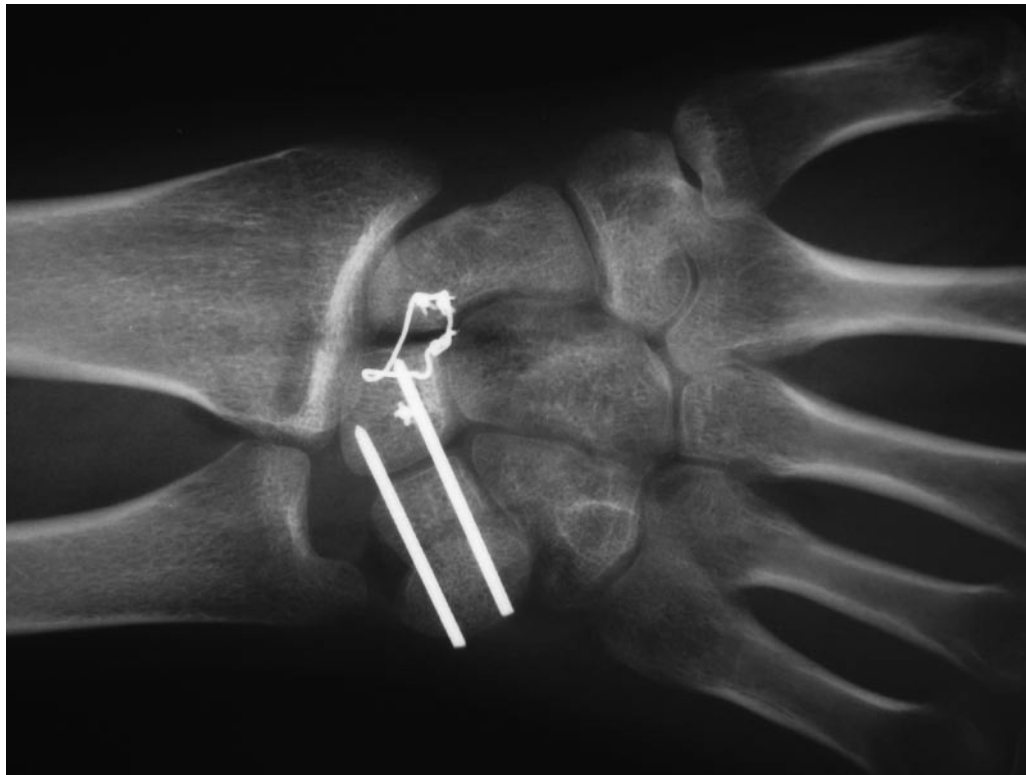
Postoperative PA and lateral radiographs of a volar lunate dislocation treated with a combined dorsal and volar approach using a 20 gauge intraosseous cerclage wire.
